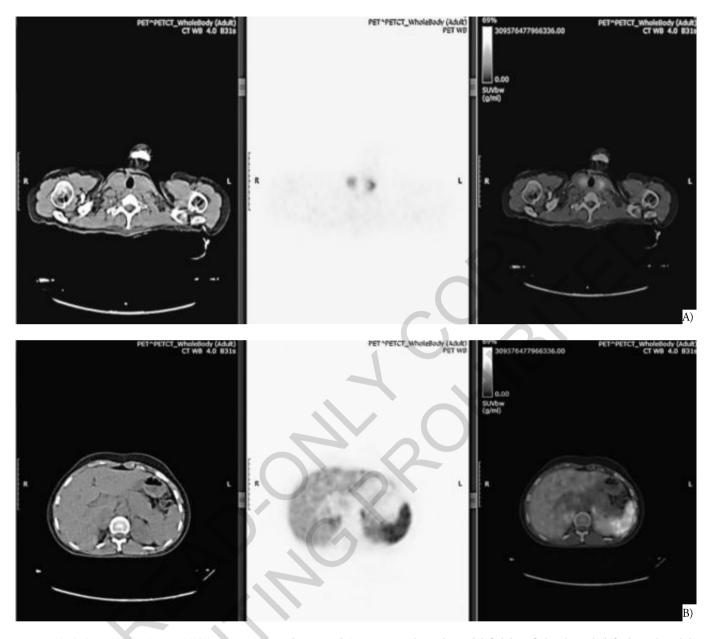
A) 68Ga-DOTATATE PET/CT imaging showed increased SUVmax at the right and left lobe of the thyroid (left thyroid nodule SUVmax: 19,4, right thyroid nodule SUVmax 21,2); B) 68Ga-DOTATATE PET/CT imaging showed right adrenal mass with a high SUVmax (SUVmax 12,4).
